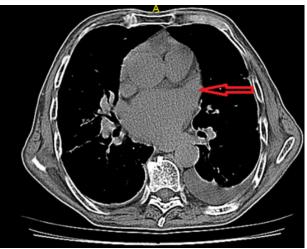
Computed tomography of the heart. Increased side of the left atrial appendage. It can be also visible on a chest X-ray at the level of the "gulf of the heart".
